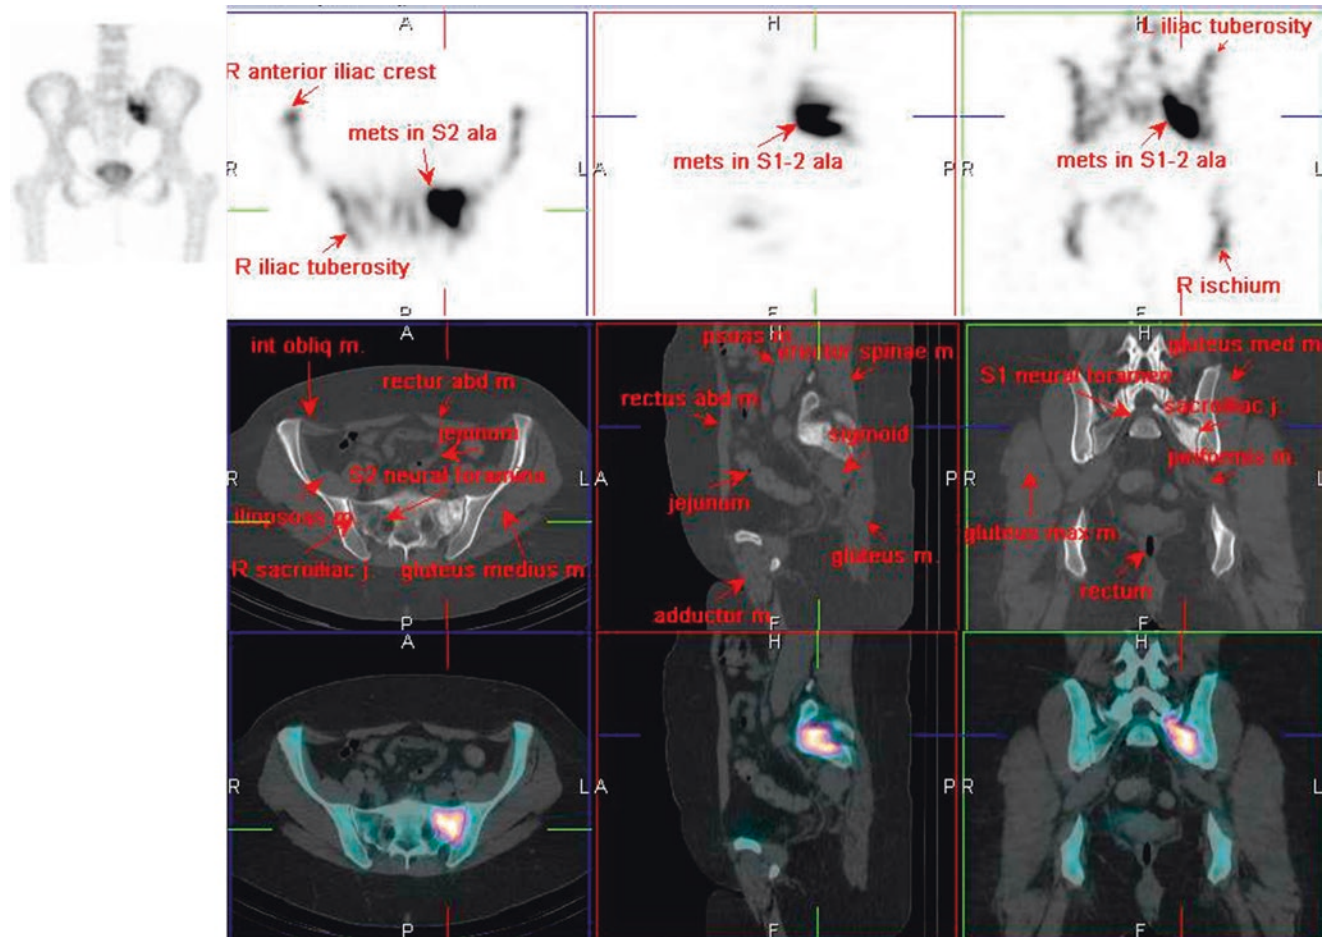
^{99m}Tc-MDP SPECT/CT
